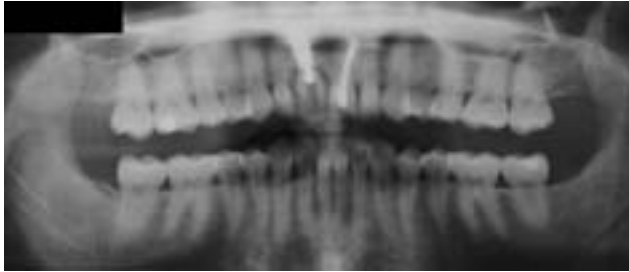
Panoramic radiograph showing malpositioned implant 8, inserted too far apically.
